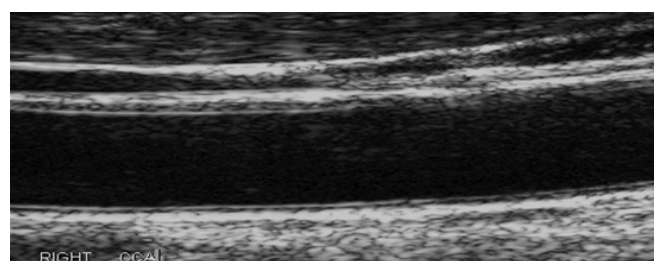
Ultrasound scan of the carotid artery of Athlete 3 [Note the smooth non-calcified vascular wall]
